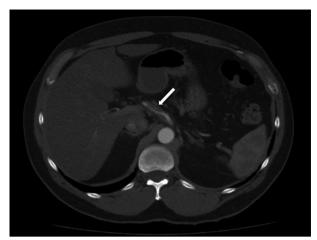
Abdominal CTA taken at admission showing celiac artery dissection with extension of intramural hematoma into the hepatic artery.
